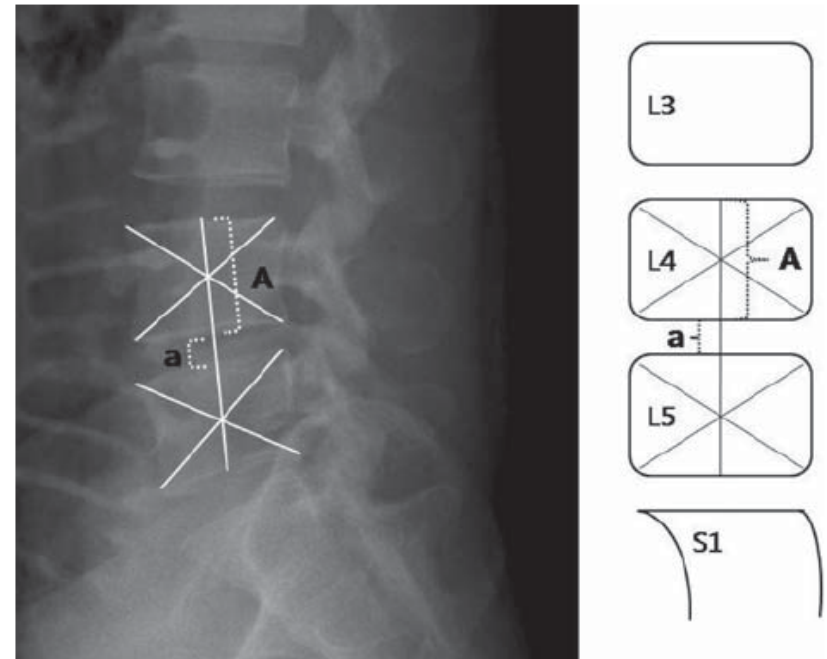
Radiographic measurement of the disc height index (DHI). Heights of the vertebral body and disc are measured using the midvertebral line. The midvertebral line is the line connecting the L4 and L5 centers. The center of the vertebral body is a crossing point of 2 diagonal lines of each vertebral body. $DHI = a/A$.
